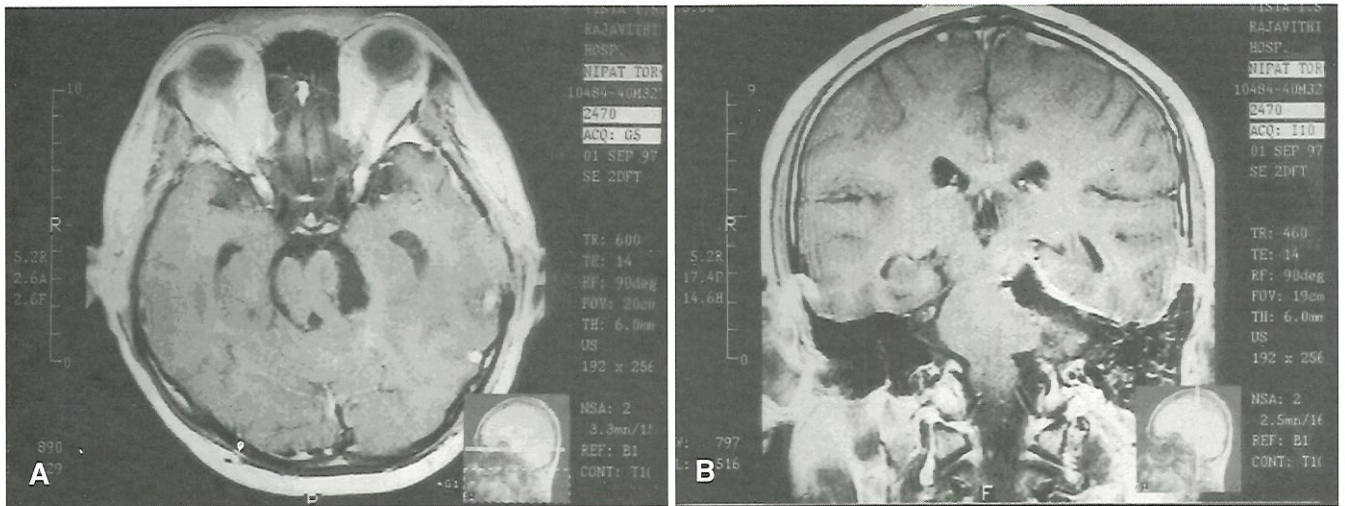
Postoperative MRI revealed total tumor removal.
